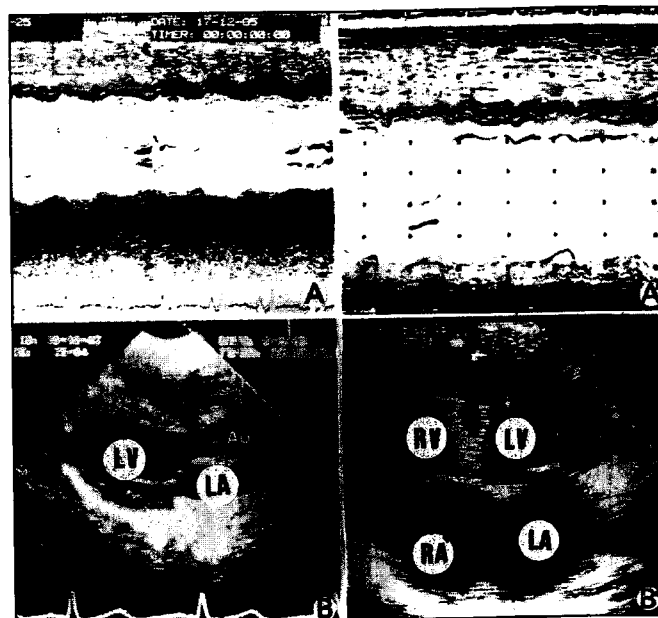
Patient No. 12. Echocardiogram before (A, B) and after (A', B') l-carnitine treatment for three months. A: M-mode recording of left ventricular cavity showing important dilatation and mitral valve posterior displacement. B: bidimensional longitudinal axis, parasternal projection showing marked left ventricle dilatation. A': type B paroxistic movement of interventricular septum, even though ventricular function shows an improvement. B': apical chambers projection, showing left ventricular cavity dilatation. LA: left atrium, LV: left ventricle, Ao: aorta, RA: right atrium, RV: right ventricle. This figure is reproduced from the volume «Role of L-carnitine in cardiomyopathies in infancy» presented in the World Congress of Pediatric Cardiology and Cardiac Surgery, Paris, June 21-25, 1993, with the kind authorization of Dr. J. P. Bonnefont of the Hopital Necker enfants-malades of Paris, and Sigma Tau of Rome.
